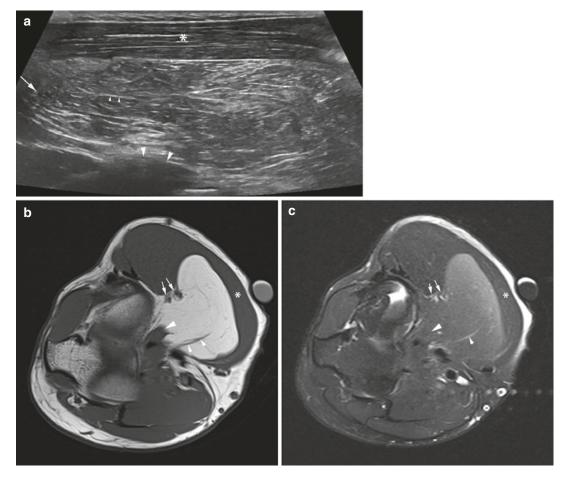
(a–c) Intramuscular lipoma of the right arm. (a) Ultrasound. (b) Axial SE T1-weighted MR image. (c) Axial fat-suppressed SE T2-weighted MR image. On ultrasound the mass is homogenous and hyperechoic (a), and the signal intensity on different MR sequences equals
